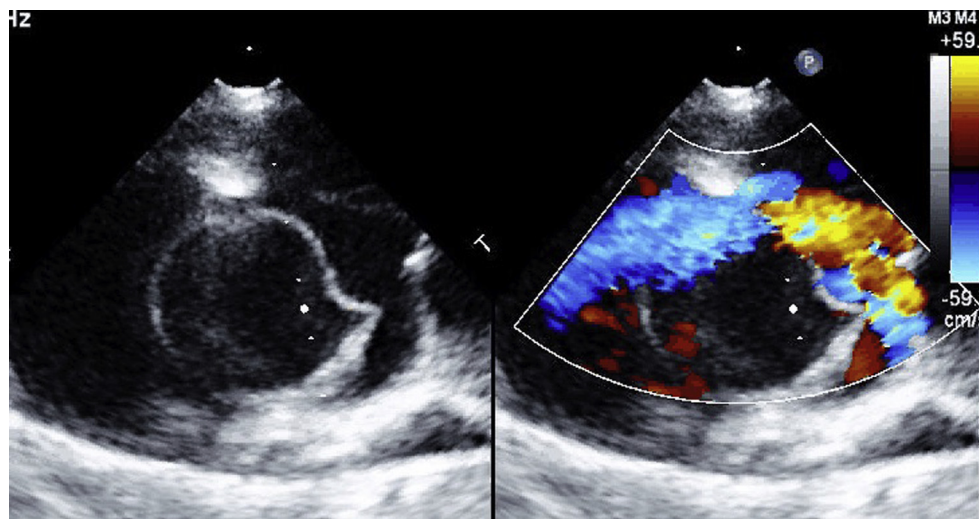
Transthoracic echocardiogram: short-axis view of the heart showing the intramural hematoma/dissection flap in the right atrium above the level of the tricuspid valve with simultaneous color Doppler demonstrating blood flow around the dissection but not inside it.
